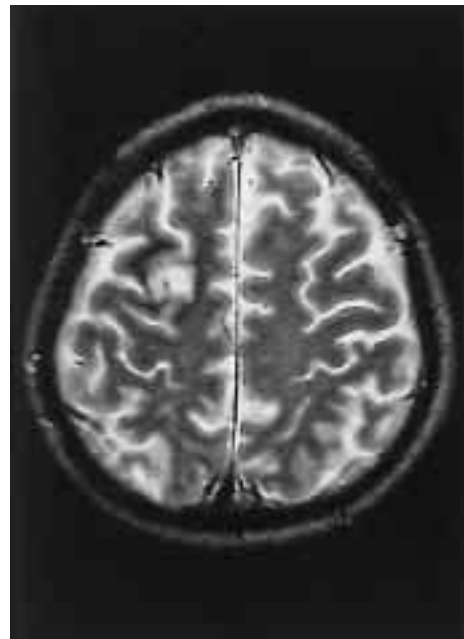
T2-weighted image in brain MRI obtained on March 5. In comparison to Figure 2, the abnormal intensity is found to be decreased in size.
